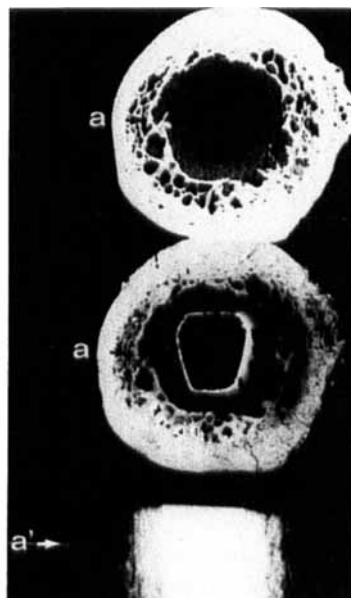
Cross section at white arrow level in Figure 5. The well-developed circumferential neocortical sheet anchoring the implant (a) is not detectable on the plain radiograph (a').
